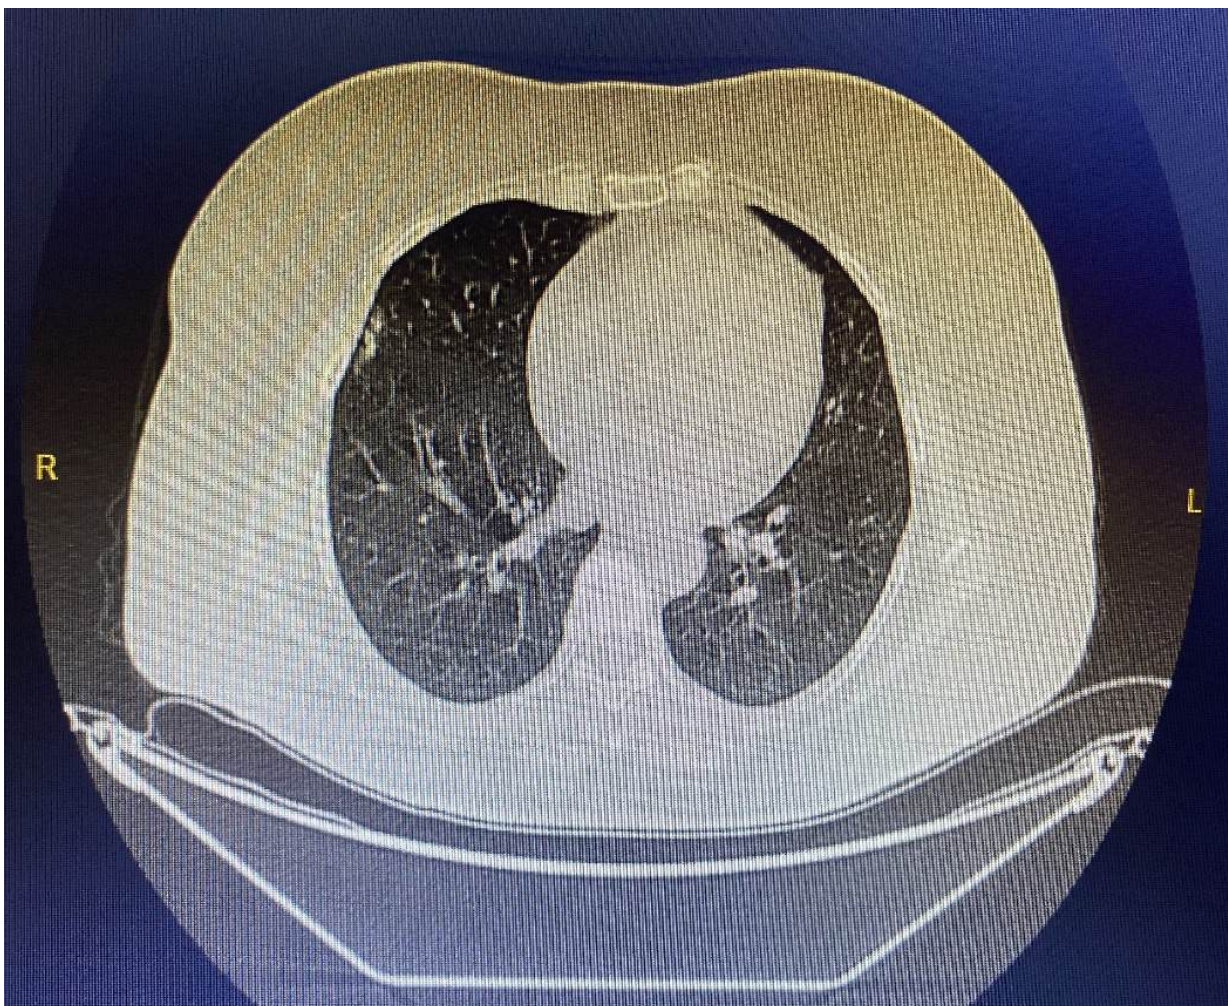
Thorax CT: Small infiltrative area in middle lobe lateral segment.
